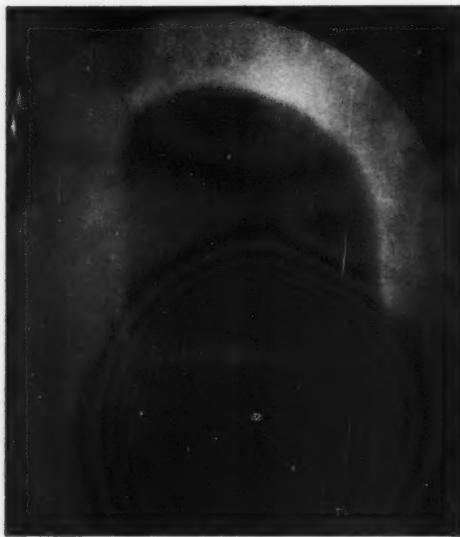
Erect cholecystogram to demonstrate minute cholesterol calculi which float between biles of different concentrations, at their interfaces. (Re-produced through courtesy of Dr. Alice Ettinger and the "American Journal of Roentgenology and Radium Therapy.")
